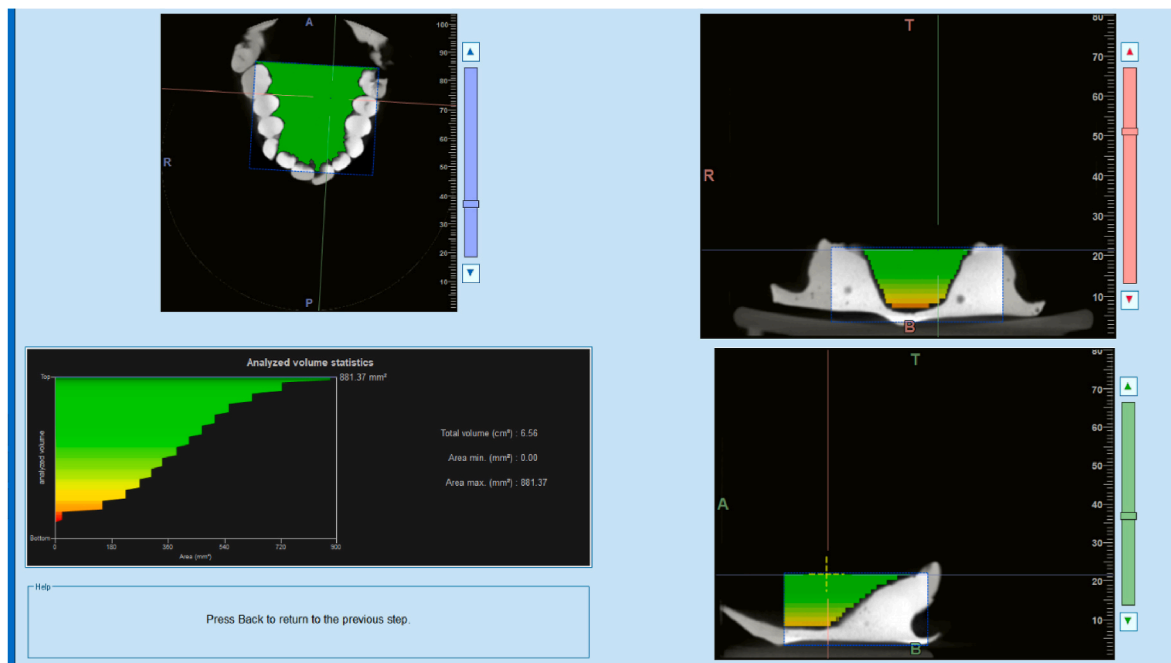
Measurement of the palatal volume by the conventional method by determining the planes and boundaries on the CBCT scan of the pre-treatment models.
